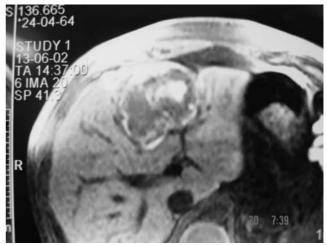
T2-weighted liver MR image shows a hyper-intense mass located in segment IV
